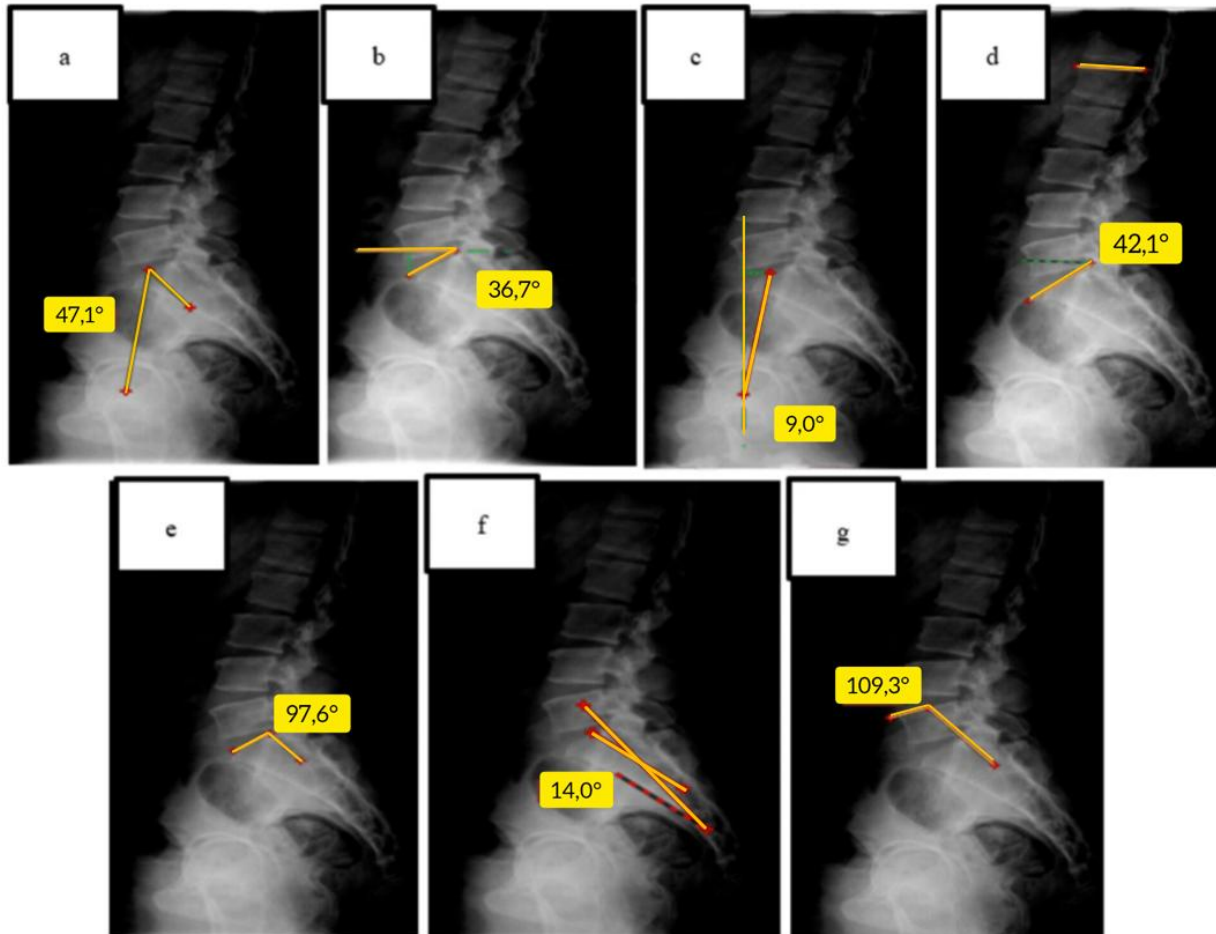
Measurement of spinopelvic parameters on lateral lumbosacral radiography: (a) Pelvic Incidence, (b) Sacral Slope, (c) Pelvic Tilt, (d) Lumbar Lordosis, (e) Sacral Table Angle, (f) Sacral Kyphosis, (g) Lumbosacral Angle (Ru et al., 2021; Lee et al., 2022; Jakob et al., 2023)
